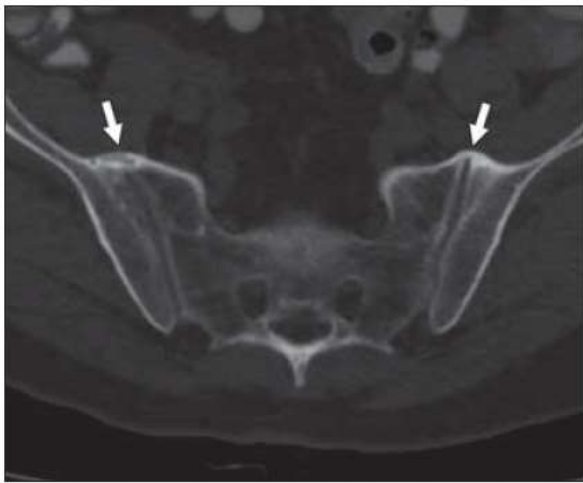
75-year-old man with diffuse idiopathic skeletal hyperostosis. Axial CT image of sacroiliac joints (SIJs) shows bilateral anterior bridging (arrows). There is some iliac cortical irregularity with subchondral cysts in right SIJ and no evidence of intraarticular abnormality in left SIJ.
